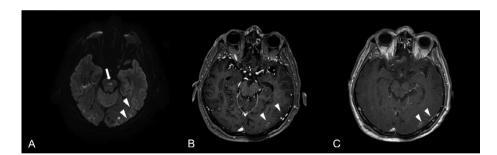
(A) The DWI map detects a signal restriction of the cortex in a parietal region characterized by weak hyperintensity (arrowhead) probably due to signs of cortical inflammation. In addition, the presence of signal restriction areas at the pons level (arrow) and in the parieto-occipital area (arrow) is observed, such as for ischemia in the subacute phase. (B) The same section is performed after administration of contrast medium and reveals leptomeningeal enhancement (arrowhead). (C) Contrast enhancement was best emphasized with late acquisition after administration of contrast medium (arrowhead).
